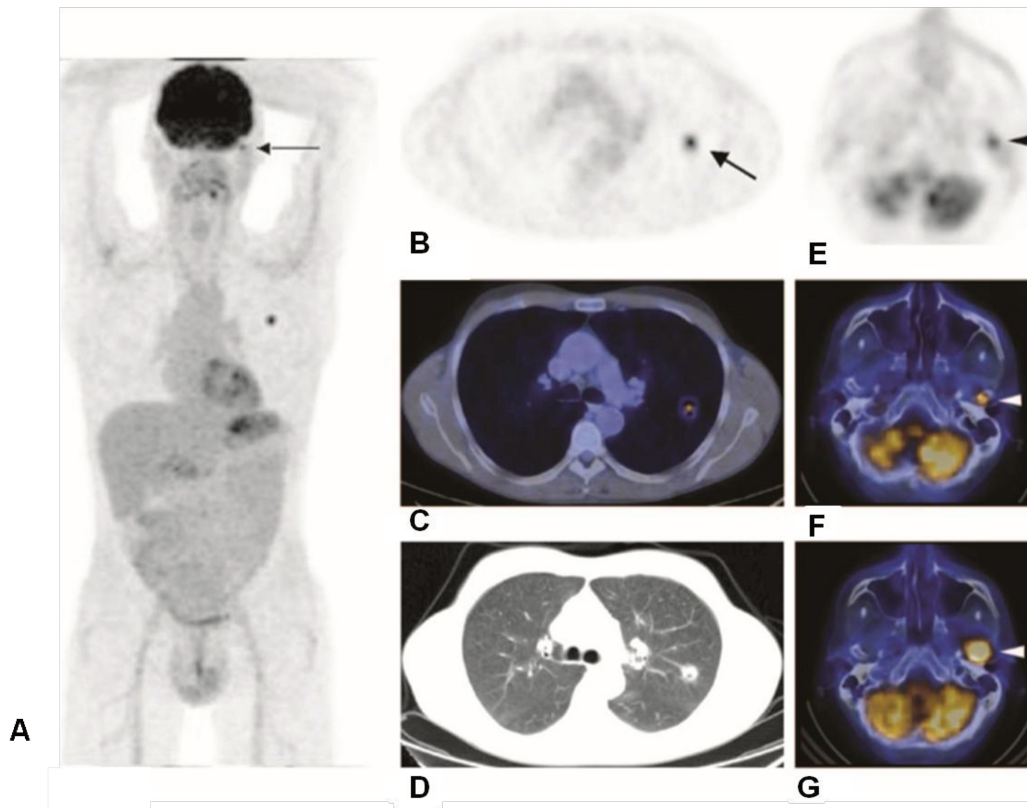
Non–small cell lung cancer (arrow in B) in the left upper lobe is shown in (A) coronal PET maximum intensity projection and (B) transverse PET image, (C) transverse PET/CT image, and (D) transverse CT lung window image. (E) Transverse PET image shows small focus at left skull base (arrowhead, arrow in A); (F) on transverse PET/CT scan, focus appears to be a bone metastasis (arrowhead) in the mandibular condyle. (G) This was confirmed with follow-up transverse PET/CT, where interval growth of the lesion (arrowhead) was seen. Reproduced from ^[14].
